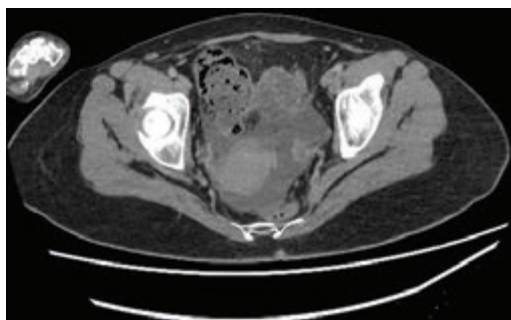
Axial contrast enhancing computed tomography image that shows free fluid was present in the pelvis.
